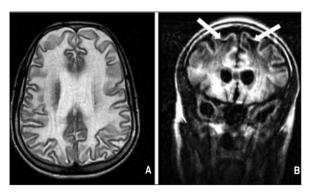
Ten years later, at the age of 29 years, brain MRI showed no difference when compared to the previous scan, other than mild increase in cerebral atrophy and the appearance of tiny frontal subcortical cysts (arrows in B). White matter shows diffuse hyperintensity on T2 weighted axial image (A), bilateral temporal cysts persist on coronal FLAIR image (B).
